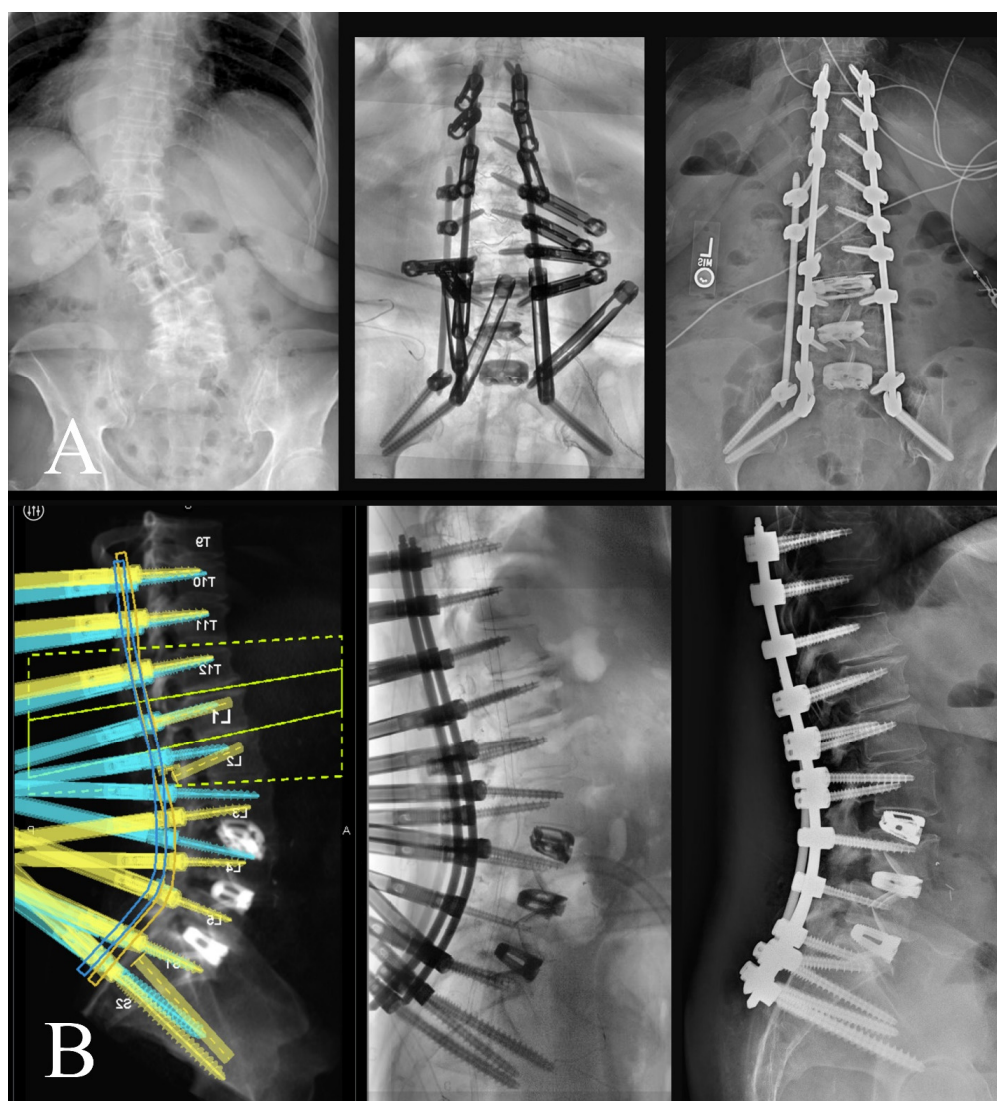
(A) (left) Preoperative AP X-ray; (middle) intraoperative AP long film showing appropriate coronal correction; (right) postoperative standing AP X-ray. (B) (left) Preoperative robotic plan with patient-specific rod geometry; (middle) intraoperative sagittal long film with appropriate sagittal correction; (right) postoperative standing lateral X-ray.
